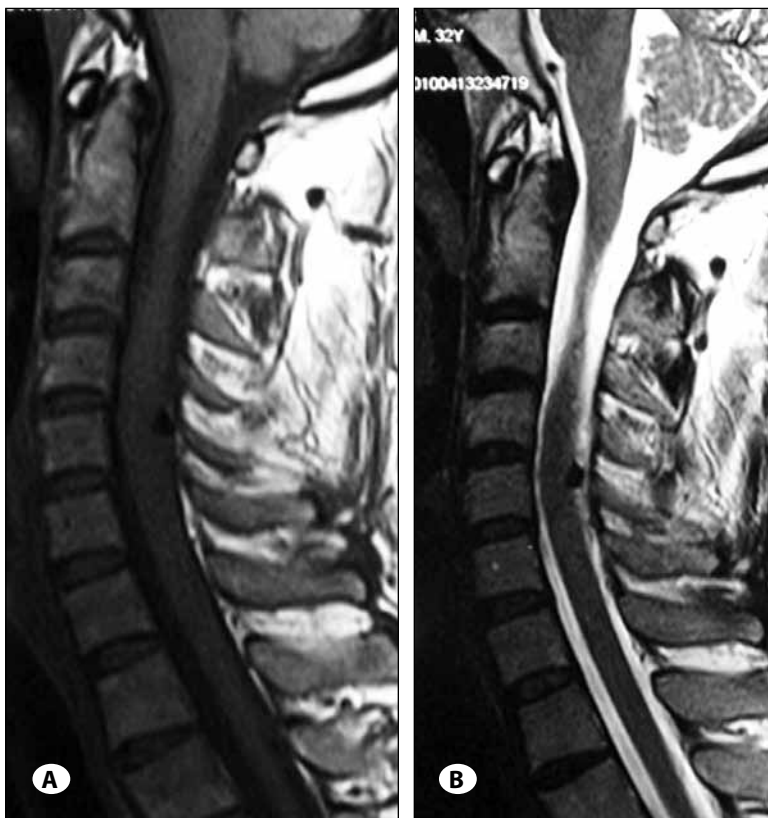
T1-weighted (A) and T2-weighted (B) sagittal MRI scans showing a hypointense lesion behind the spinal cord.
